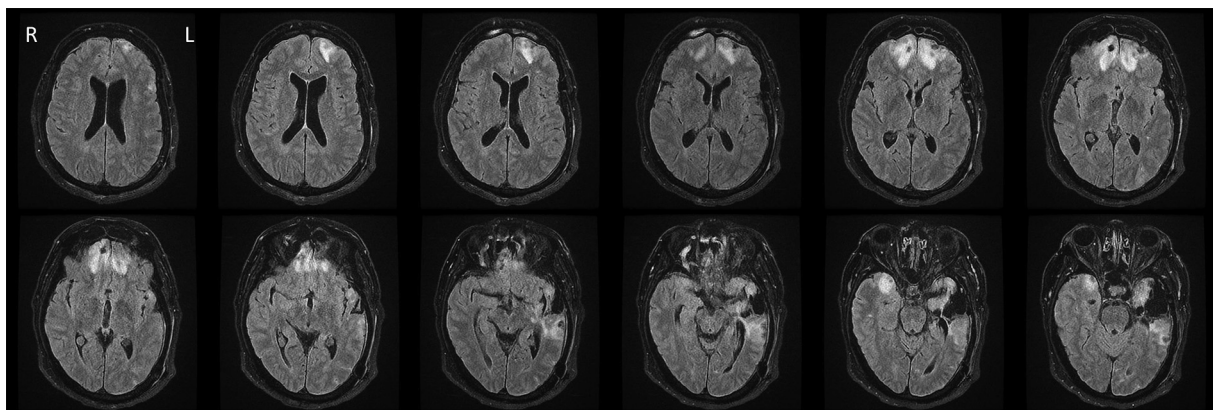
MRI of the Brain Post-TBI. Note. Axial T2 FLAIR without contrast two days post-TBI.
